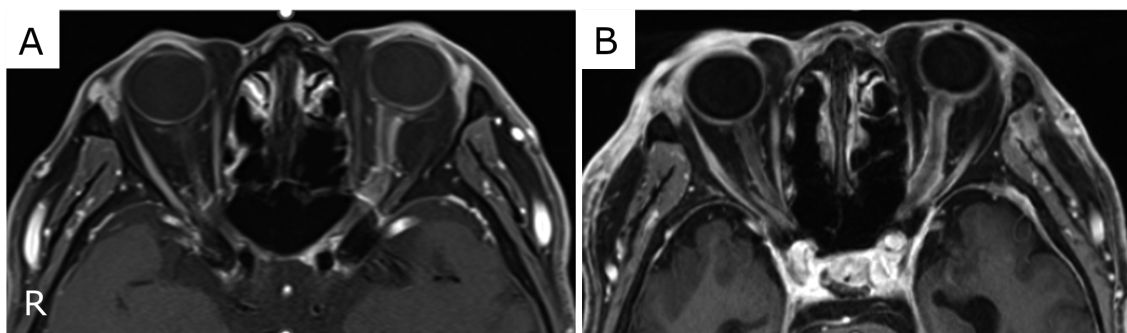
Cranial contrast-enhanced MRI showing enlargement of the left optic nerve sheath with contrast enhancement, compared to the right (A). Repeat contrast cranial MRI 3 months later showed an enlarged optic nerve sheath with cavernous sinus involvement (B).
